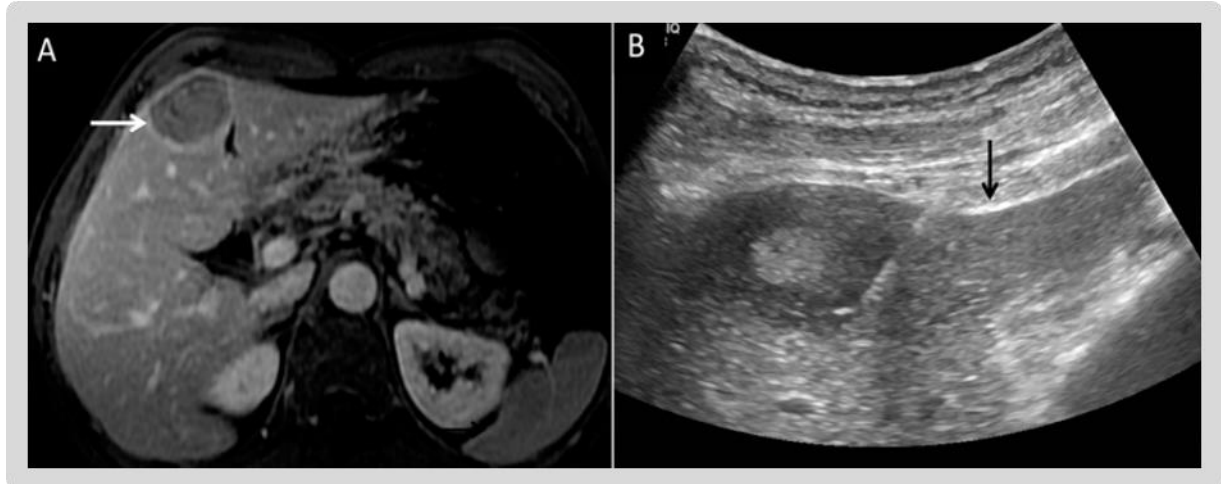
Hepatic Ultrasound image. A) Image showing metastatic lesion (arrow) in the medial segment of the left lobe of the liver. B) Ultrasound-guided core biopsy of the same lesion was performed, confirming metastases. The arrow points to the needle (Image sourced from Balasubramanya et al. 2016).
